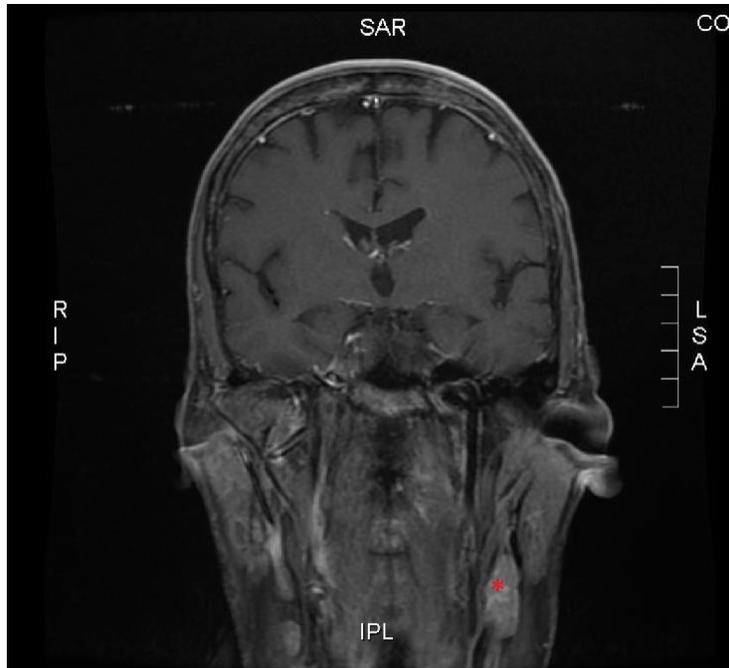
MRI displaying left sided enlarged enhancing jugular lymph node (red star).
